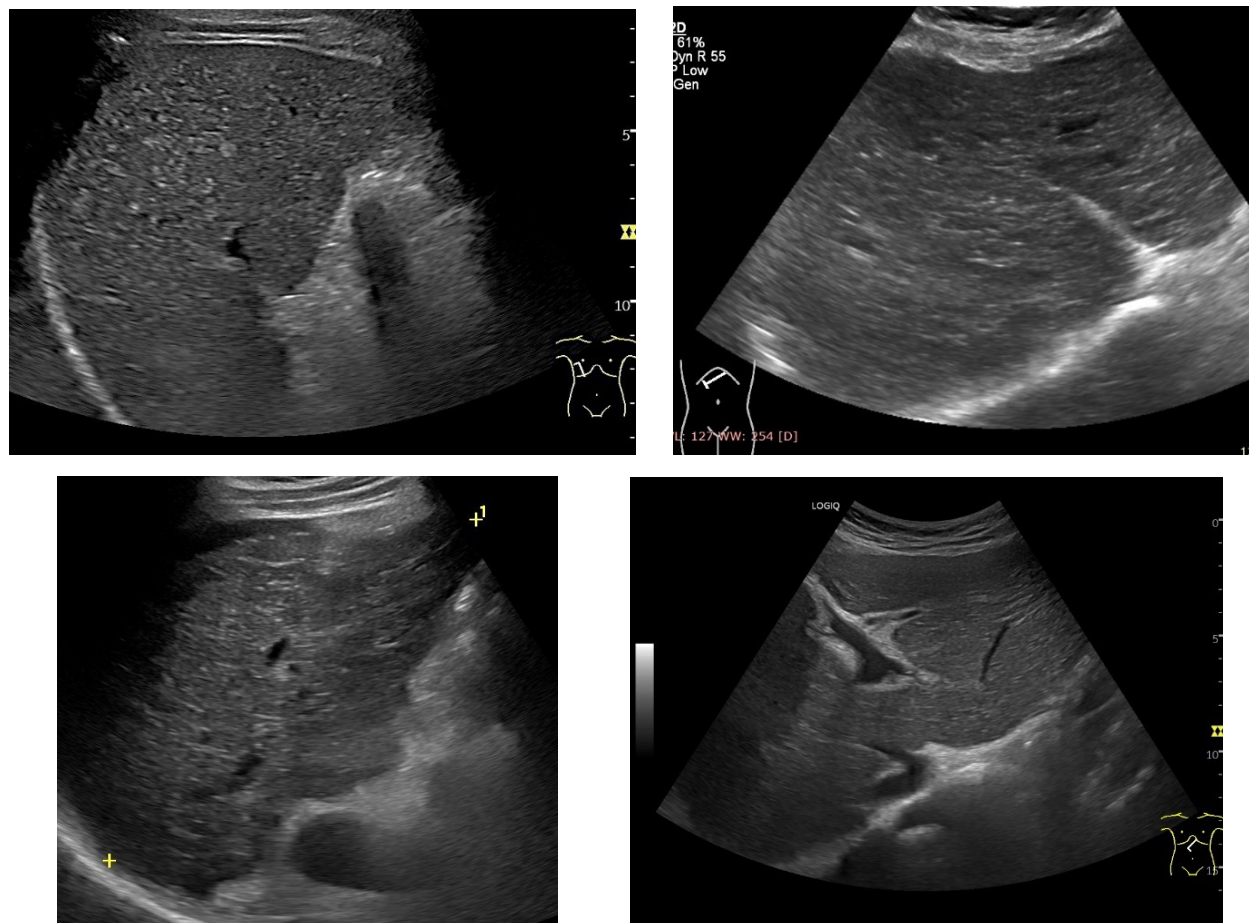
A-D. These B-mode ultrasound images show a heterogeneous (inhomogeneous) hepatic parenchyma and an irregular, nodular liver surface, both classic features of cirrhosis reflecting advanced fibrotic changes.
